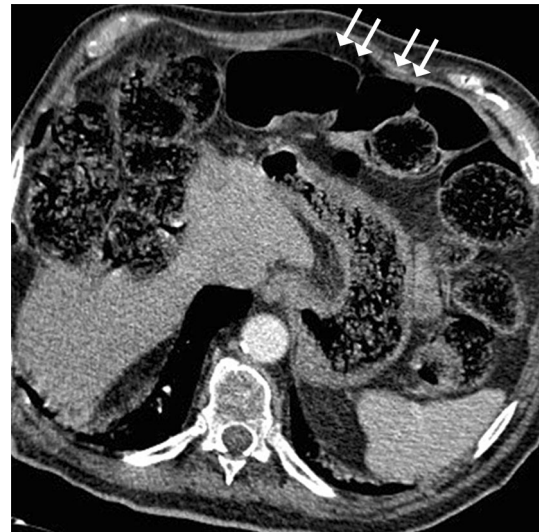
A 75-year-old male with history of stroke referred for percutaneous gastrostomy tube placement. Review of the previous CT images showed interposition of the transverse colon (*arrows*) between the stomach and anterior abdominal wall precluding safe percutaneous gastrostomy insertion. The patient was referred for surgical gastrostomy
